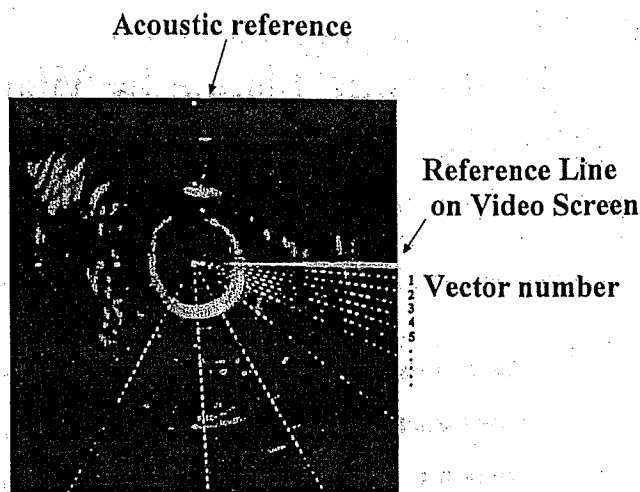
Acquisition of radiofrequency intravascular ultrasound signals. There are 256 radial vectors of radiofrequency signal sampled around the intravascular ultrasound catheter.
